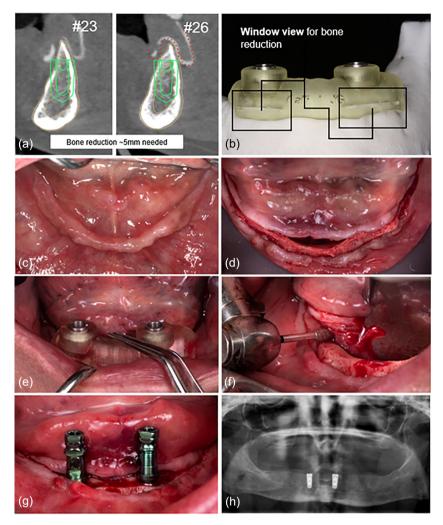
Case 4, a 77-year-old female patient: (a) the ridge height was planned to be reduced by around 4–5 mm by the use of the surgical guide; (b) the 3D-printed surgical guide, with two horizontal window openings at the level of implant, seating on the 3D printed mandible model; (c) preoperative clinical photograph of the lower ridge; (d) crestal flap raised exposing the thin bone; (e) the guide was placed to markup the bone reduction line; (f) alveoloplasty protocol was performed; (g) drilling protocol and implant placement; (h) final panoramic X-ray. Note the achievement of parallelism concept.
